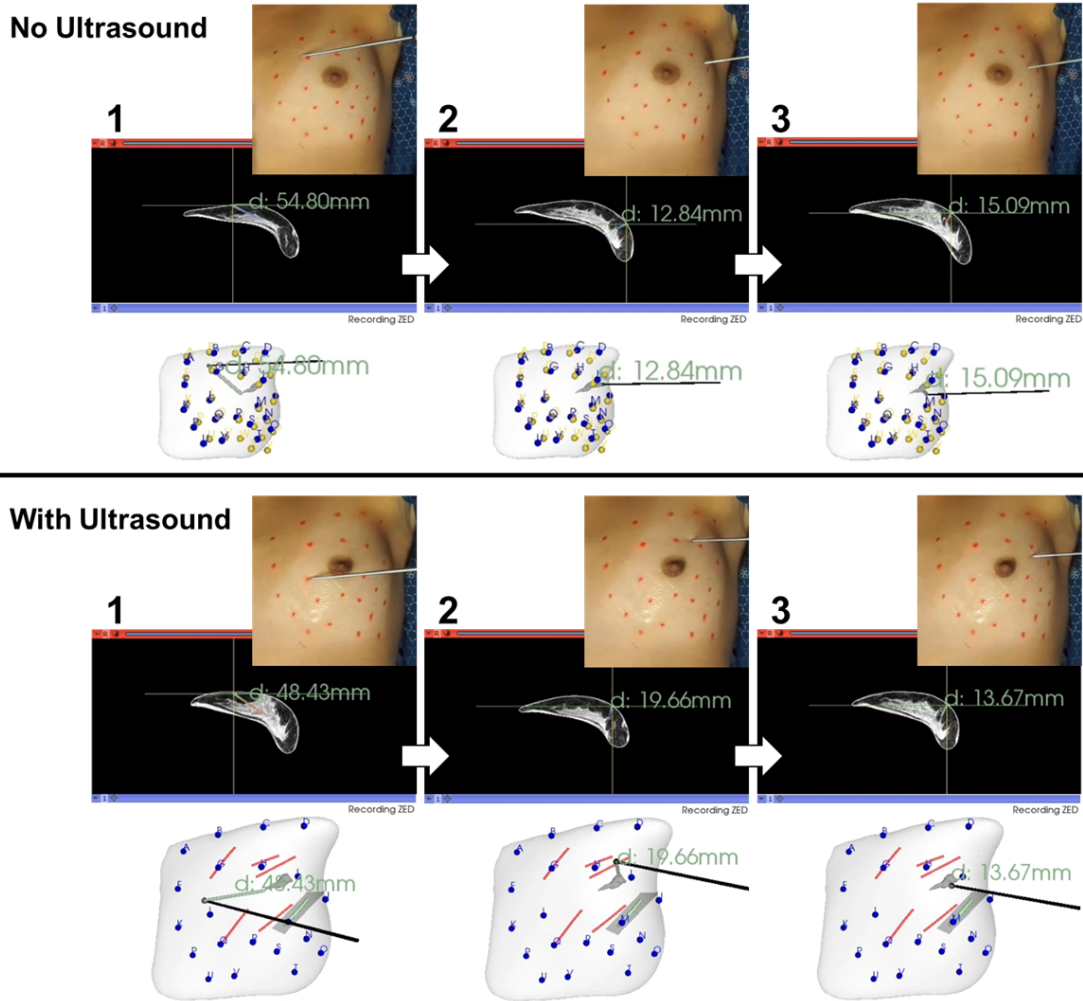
Guidance system views showing three timepoints during the healthy volunteer demonstration with and without tracked ultrasound data. Synced left stereo camera images, axial MR image slices, and the 3D scene view are displayed. The MR image, breast model, and tumor model are registered to stereo camera data of the breast geometry. The distance from the stylus tip to the mock tumor boundary during navigation is displayed in green.
